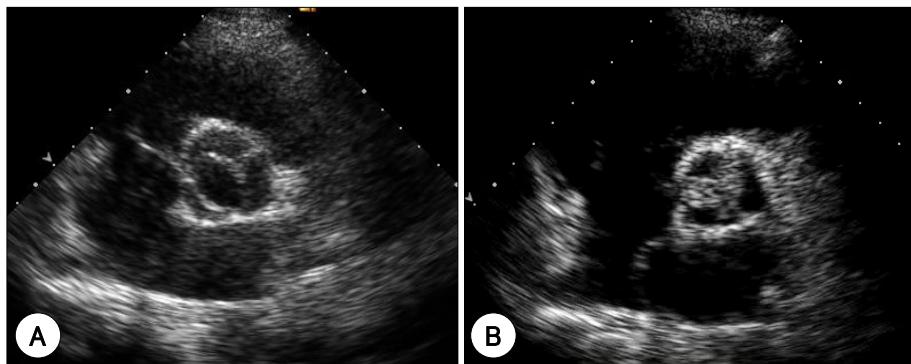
Echocardiographic finding of the aortic valve in the parasternal short axis view. The bicuspid aortic valve with fusion of the right and left coronary cusps on the initial evaluation (A) was found without evidence of any valvular mass. However, a newly developed valvular mass was found on the 1-year follow-up evaluation (B).
